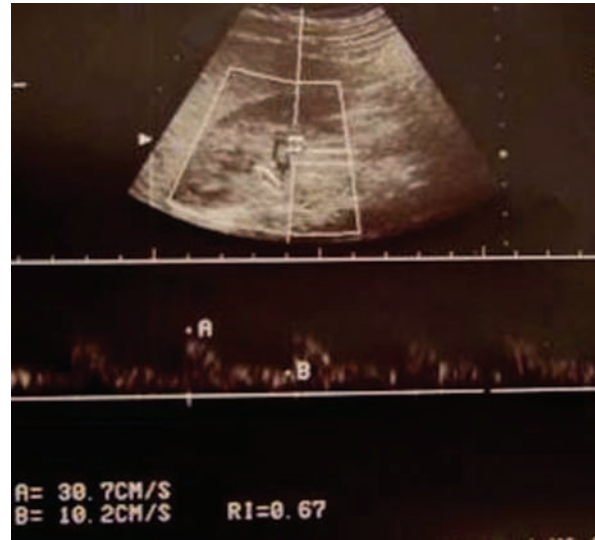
Spectral Doppler sonographic examination evaluating right kidney with grade I vesicoureteral reflux. Renal resistivity index is not increased.
